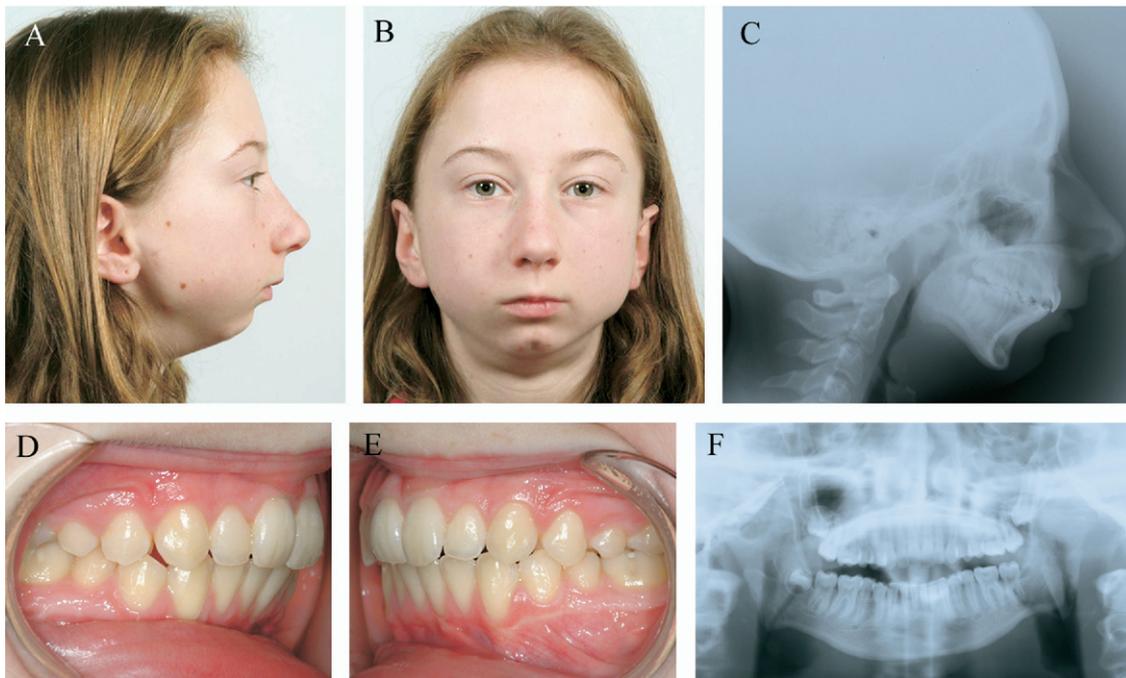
Follow-up 4 years 8 months after DO: A and B, facial photographs; C, cephalometric radiograph; D and E, intraoral photographs; F, panoramic radiograph.
